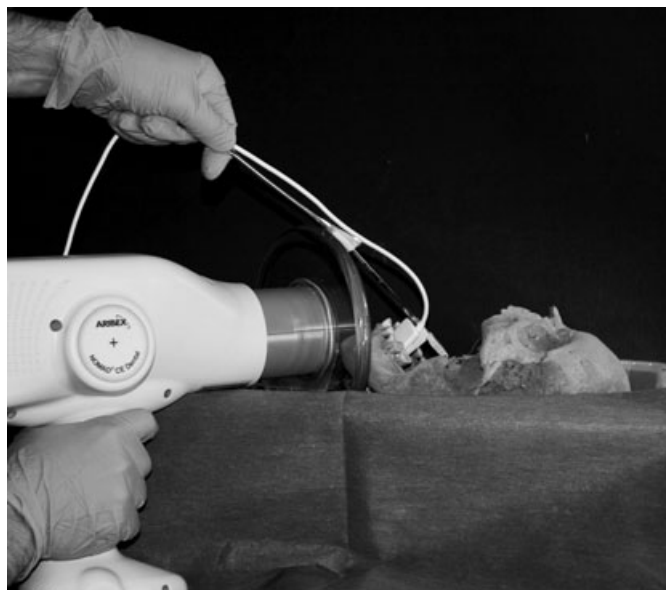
Nomad X-ray portable device combined with a sensor connected to a notebook, while examining the skull, stored in the Museum of Prehistory in Florence.
